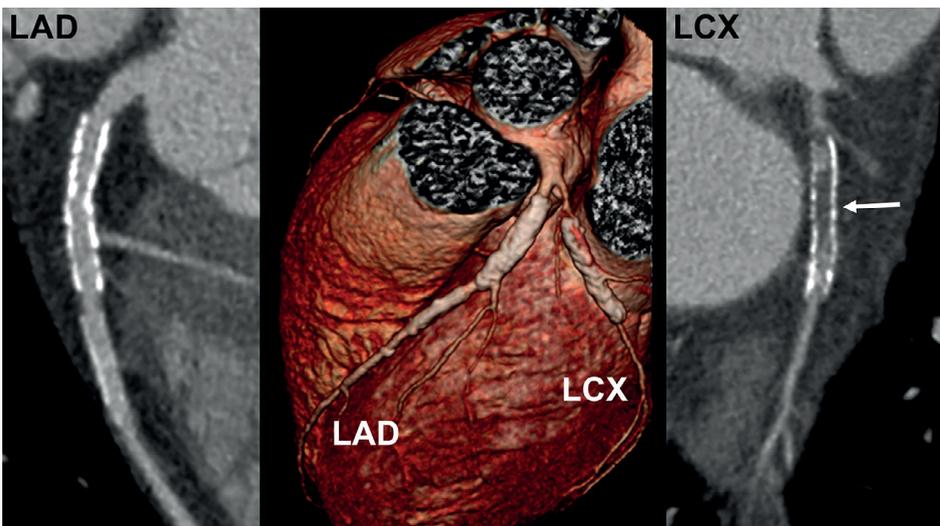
CT stent imaging. Two patent stents in the left anterior descending coronary artery (LAD). The different intensity of the stent struts on CT suggests they are stents of a different type. A septal branch is preserved after stenting. A third stent has been implanted in the left circumflex branch (LCX). The low-density material within the stent suggests occlusion (arrow). Distally the LCX is opacified, likely due by collateral supply.
